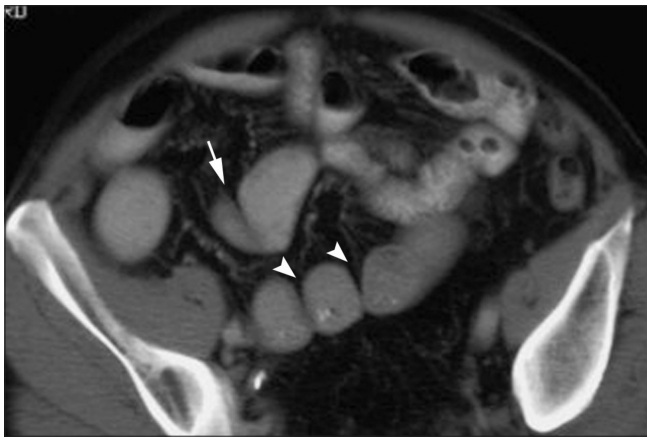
Axial CT enteroclysis examination demonstrates a segment of kinked bowel (arrowhead) and several adhesive bands across other segments (arrows). This patient had undergone several negative CT examinations previously
